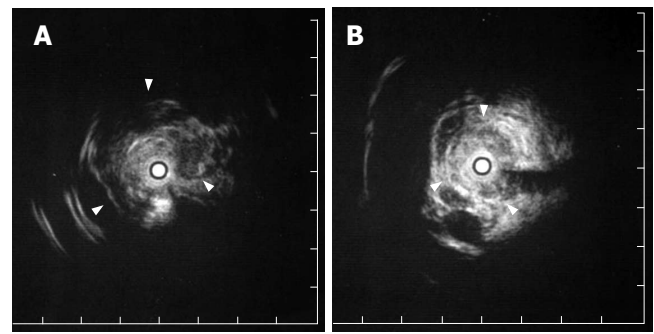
Endoscopic ultrasonography (EUS). A: Soft tissue masses at the liver hilum of the hepatic duct; B: Circumferential thickening of the common hepatic duct.
